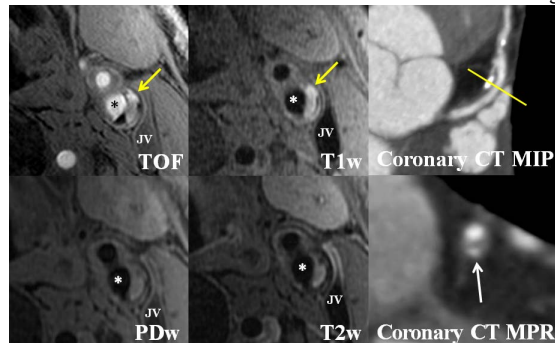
Hyperintense of IPH (yellow arrow) on TOF and T1w images was found in left internal carotid artery (star). A mixed type plaque can be observed in the same patient on proximal left anterior descending coronary artery (white arrow) on CT images. The MPR image was reformatted from the location (yellow line) on MIP image.
